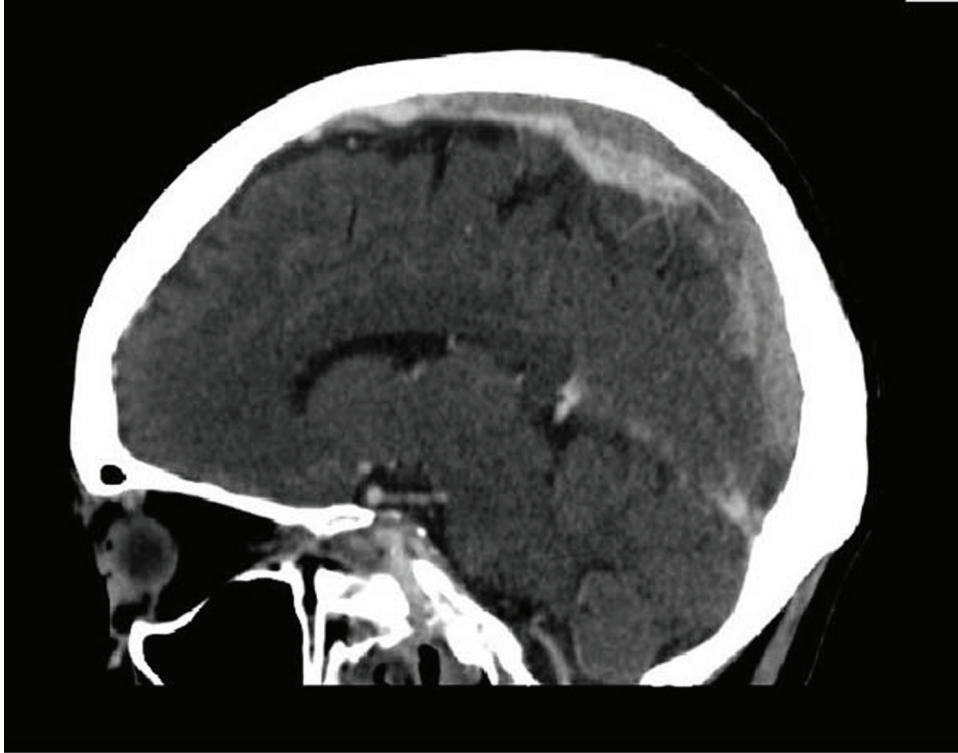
Sagittal segment CT venogram.
